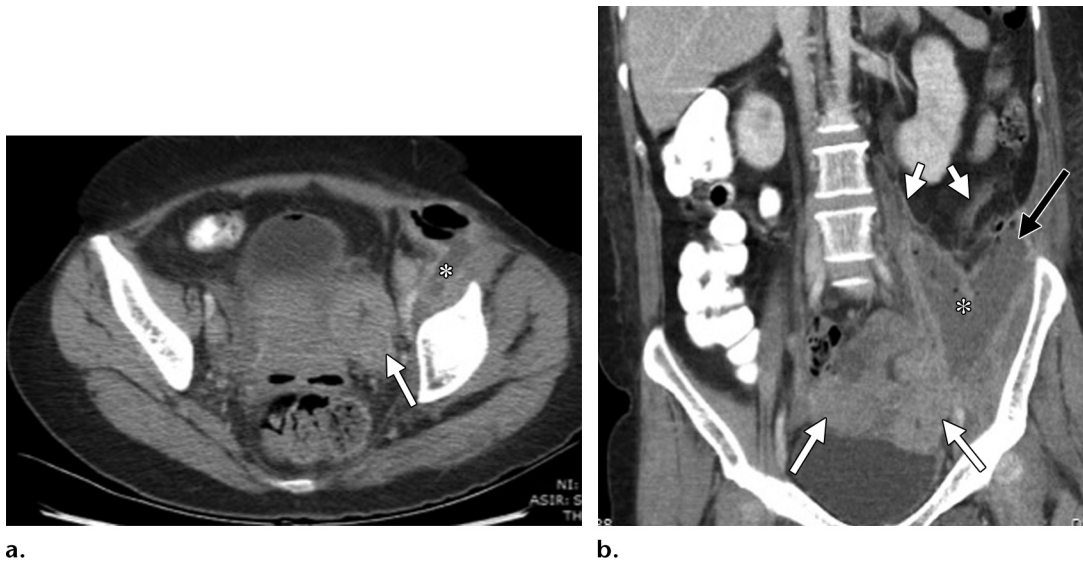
Perforated tubo-ovarian abscess in a 43-year-old woman with diabetes, abdominal pain, and fever. Axial (a) and coronal (b) contrast-enhanced CT images show bilateral tubo-ovarian abscesses (long white arrows) complicated by perforation of the left tubo-ovarian abscess with development of peritoneal fold enhancement (short white arrows on b), findings compatible with peritonitis, as well as a large complex fluid collection (*) with gas bubbles and an enhancing wall (black arrow on b) extending along the left iliopsoas muscle, findings compatible with an abscess.
